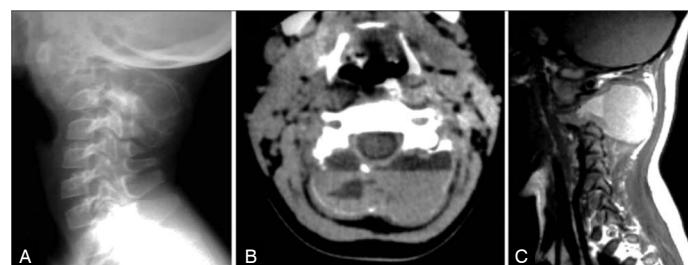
(Case 1) (A) The plain film of the cervical spine shows the "bubble" aspect of an ABC involving the vertebral body and the posterior arch of C2. Notice that the outer cortex is barely seen due the eggshell thin characteristic. (B) CT image at the level of C2 shows an expansile lytic lesion of the posterior arch with fluid–fluid levels. (C) The sagittal T1-weighted MRI shows the hyperintense fluid–fluid level inside the expanded cavity.
